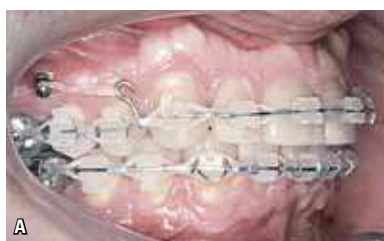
A) Mini-implant being used for total retraction on the upper arch. B) Periapical radiographic image showing sufficient space between roots as to allow a total retraction.
